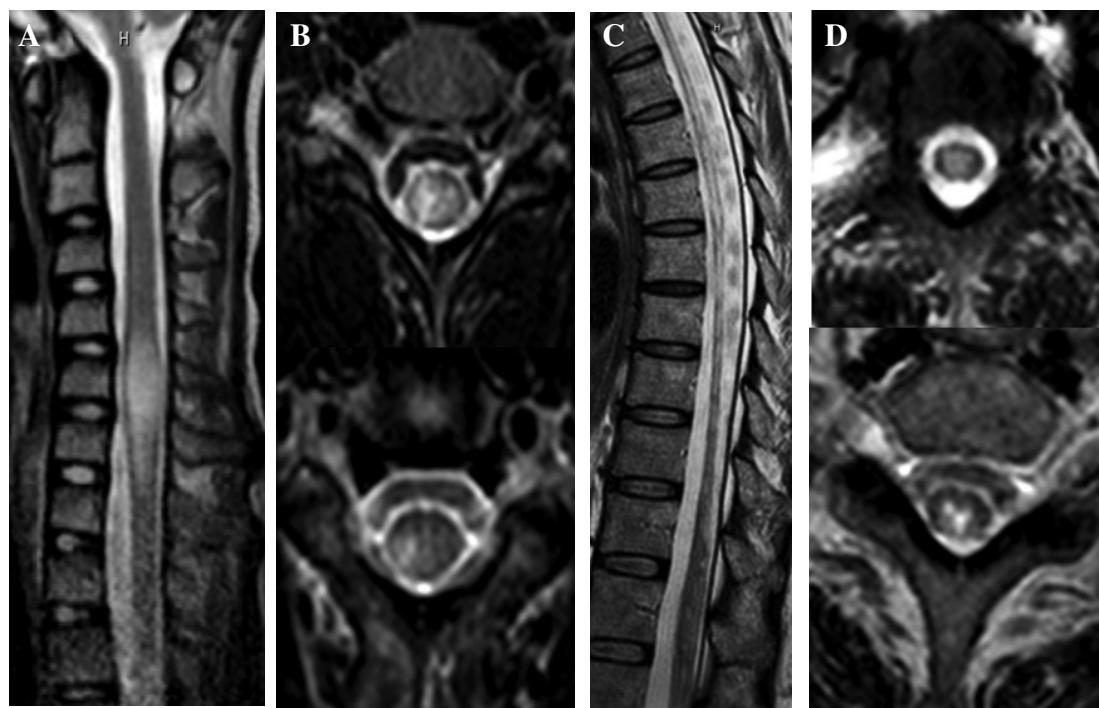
Typical spinal lesions on MRI in negative (A, B) and positive (C, D) anti-AQP4 antibody. Sagittal T2W (A) with short segment lesion at lower cervical level and axial T2W (B) the lesion locating at peripheral region are demonstrated in a seronegative patient. Another patient with long-extensive cord lesion (C) and locating at central cord (seen on D) has seropositive result.
